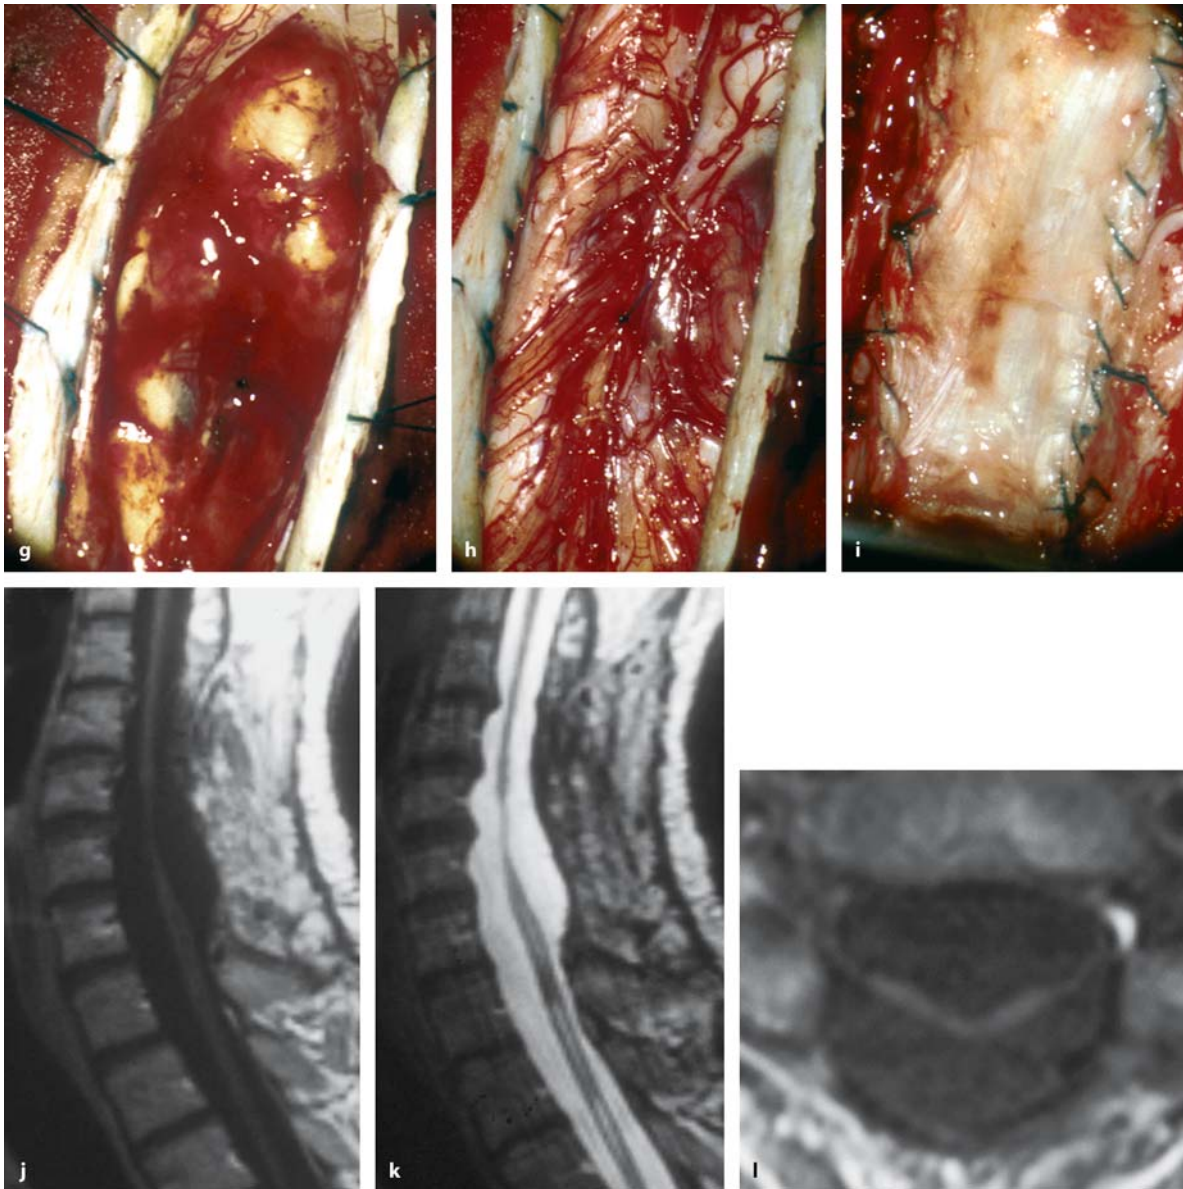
T1-weighted, contrast-enhanced sagittal (a) and axial (b) MRI images of a recurrent intramedullary ependymoma at C5–C7 in a 42-year-old man with a 4-month history of a progressive tetraparesis. The tumor is accompanied by a large syrinx. c This intraoperative view, taken with the patient in the semisitting position, demonstrates the strategy of dura opening in such cases. The previous suture line was avoided
